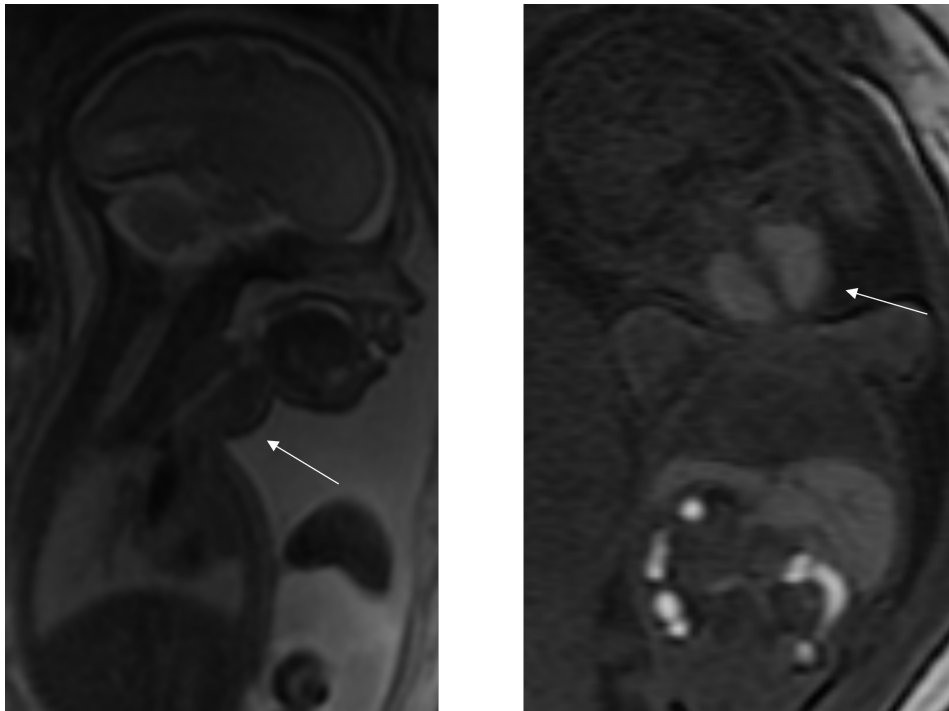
Fetal MRI images of a goitre
